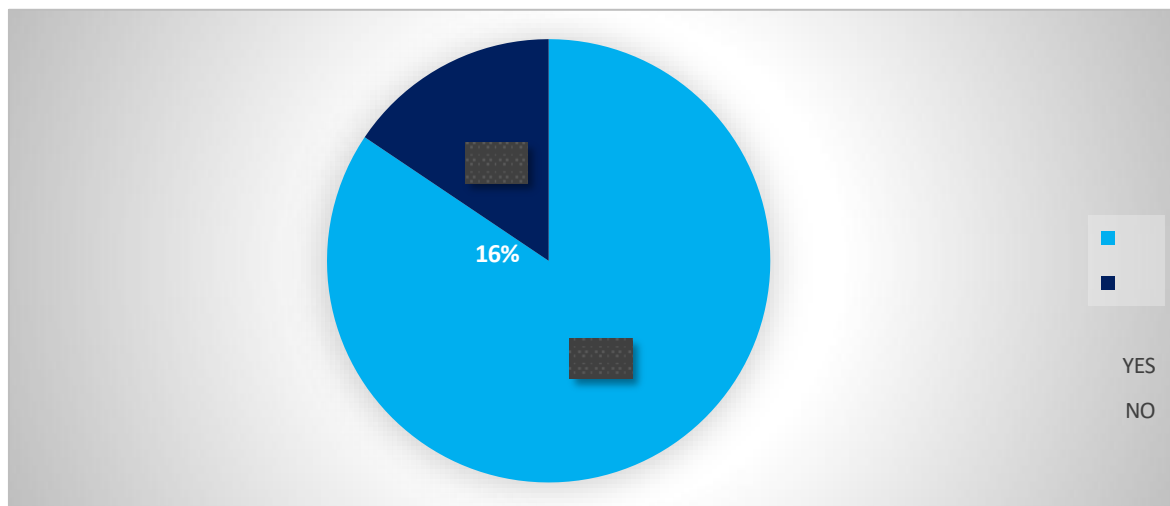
shows that the majority of the respondents (84%) had an Ultrasound Scan, whereas the minority of the respondents (16%) didn't have any Ultrasound Scan.
